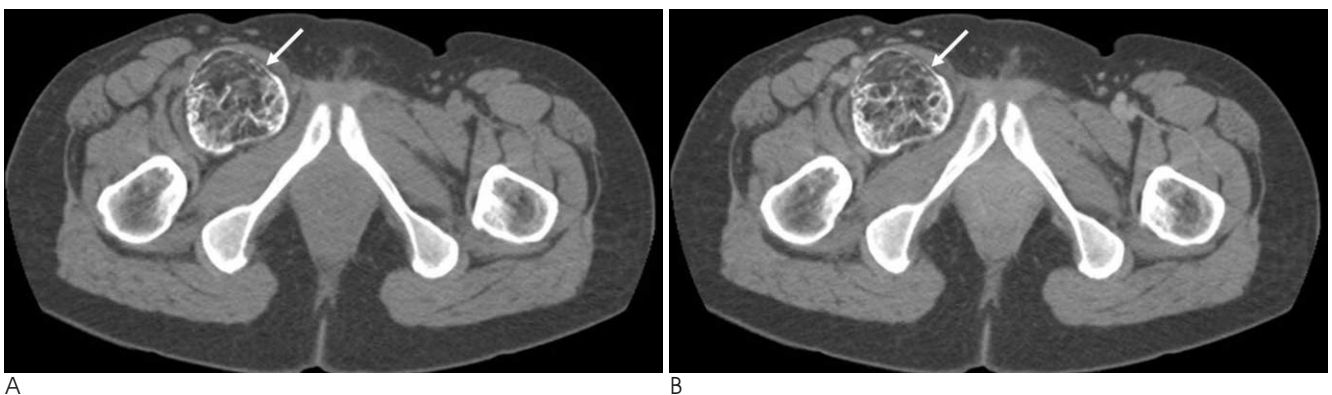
The CT Images of a 35-year-old female with ossifying lipoma in the right inguinal region.
